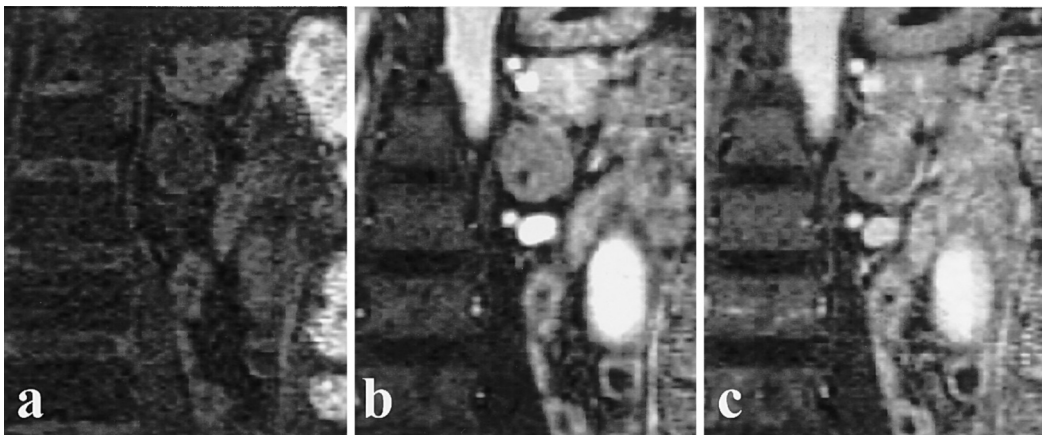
Adenoma. Dynamic contrast-enhanced images show Type I in the periphery and slow enhancement (Type 4) in the center (before (a), early (b), and delayed (c)). This central region corresponds to degeneration, which shows high signal intensity on T2-weighted images.
